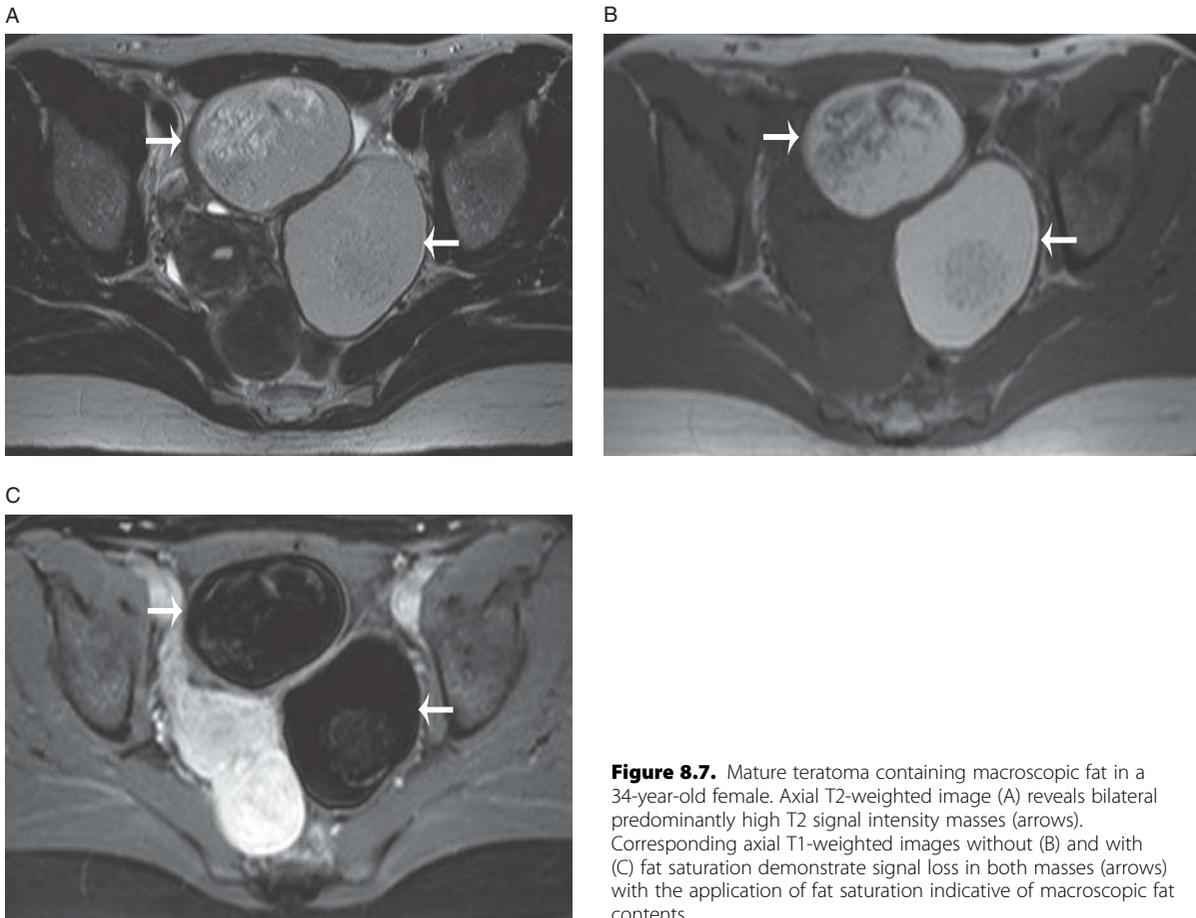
Mature teratoma containing macroscopic fat in a 34-year-old female. Axial T2-weighted image (A) reveals bilateral predominantly high T2 signal intensity masses (arrows). Corresponding axial T1-weighted images without (B) and with (C) fat saturation demonstrate signal loss in both masses (arrows) with the application of fat saturation indicative of macroscopic fat contents.
